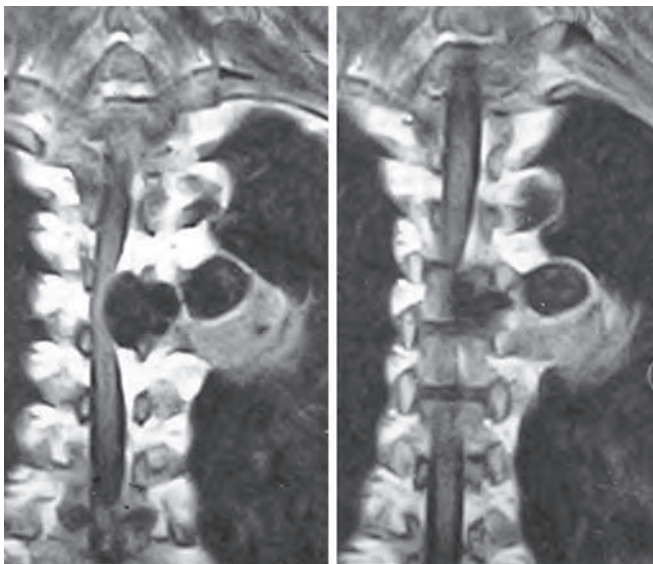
MRI showing multiloculated hydatid cyst with dorsal cord compression
